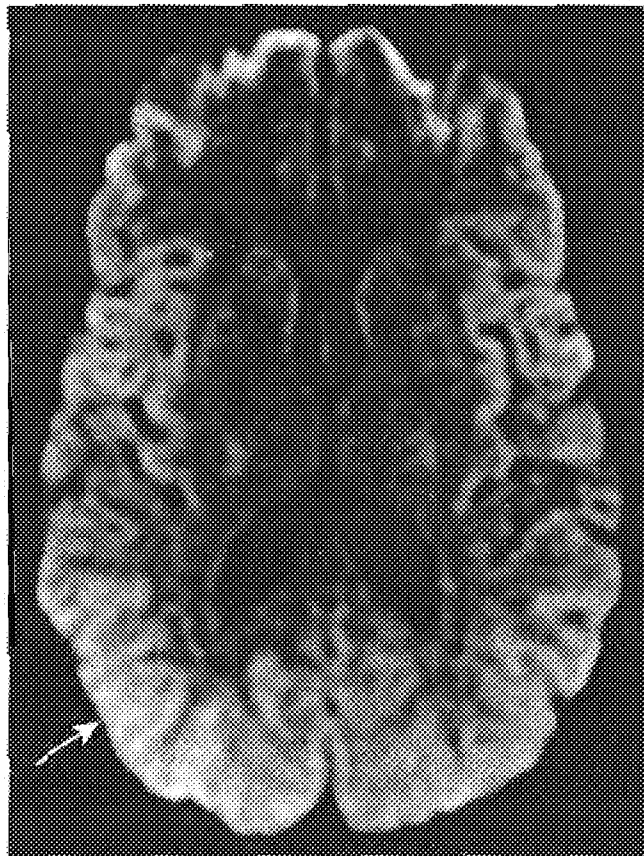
Diffusion-weighted MRI showing an area of restricted diffusion in the right temporo-parieto-occipital region (*arrow*).
